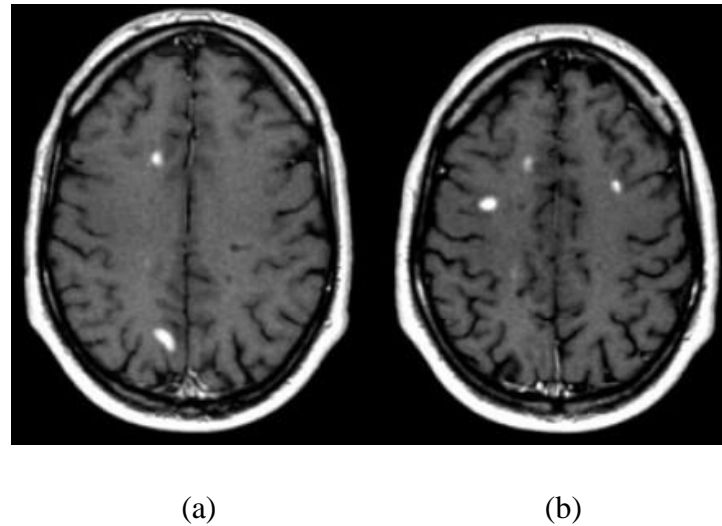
Two different time stages of an MRI brain images (axial view).
